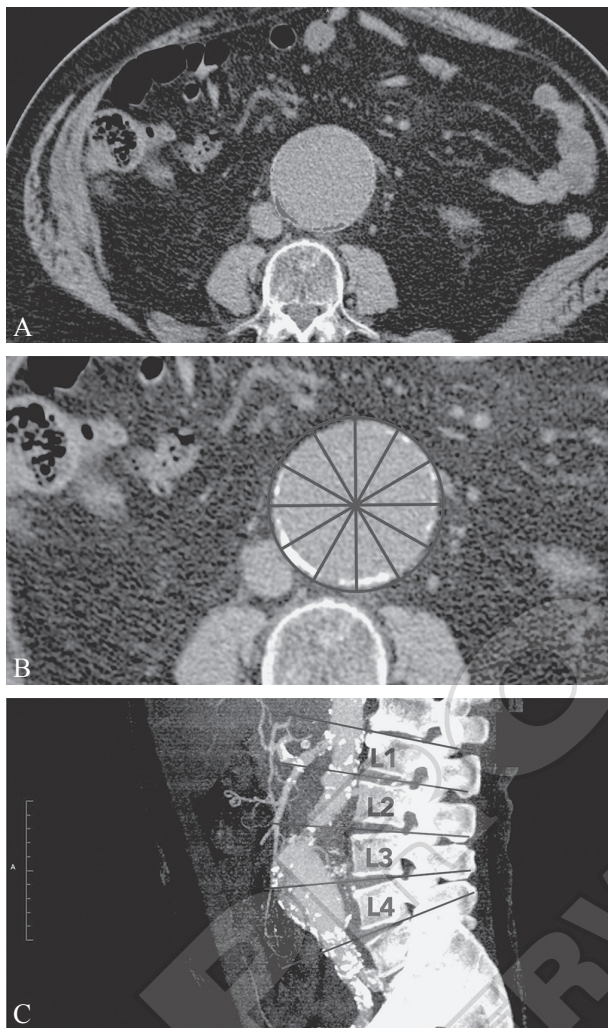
CT scan view of an AAA on the transversal plane, depicting the calcium scoring through the Agatston Score (A) and Aortic Calcification Index (B) methods. An example of a maximum intensity projection on the sagittal plane used for calcium scoring through the AAC-8 or AAC-24 methods (C).
